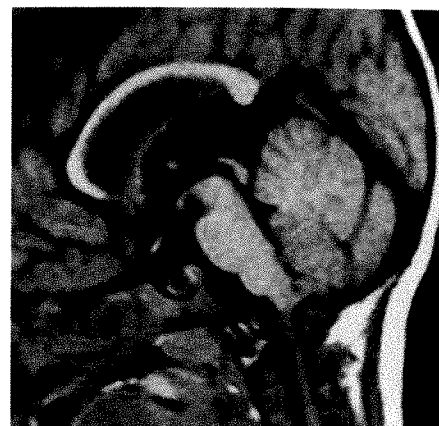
Sagittal MR image (SE 483/20) in a 10-month-old girl shows position of optic nerve and prominent straight sinus. Tentorial angle (angle A, Fig. 1) measured 70° and optic nerve–base angle (angle B, Fig. 1) measured 140° .
